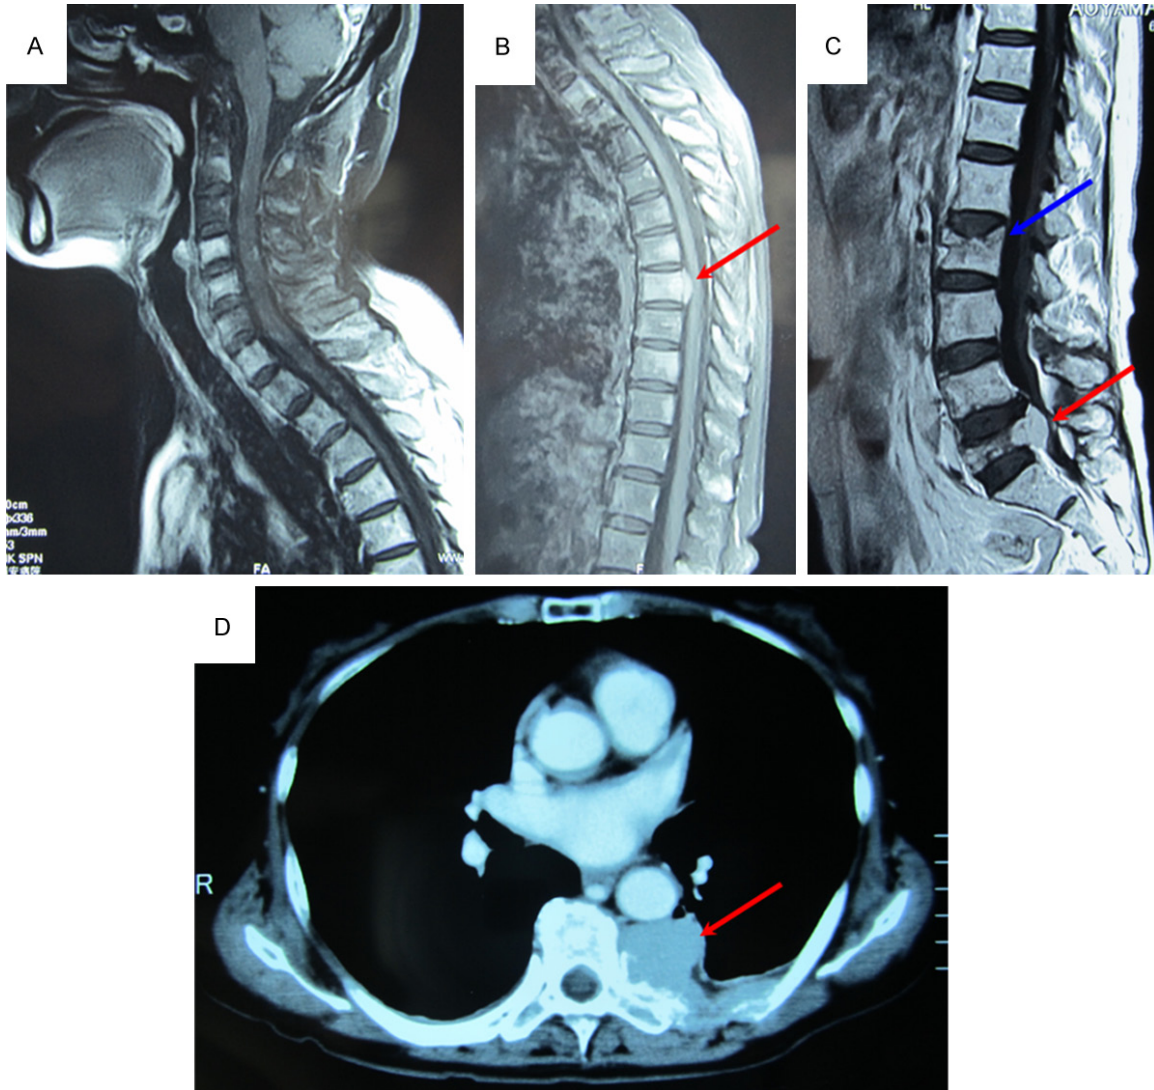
Imaging findings. A. Contrast-enhanced MRI of the cervical spine revealed many spotty signals in the cervical spine vertebral bodies, which were enhanced by gadolinium. B. Contrast-enhanced MRI of the thoracic spine revealed many spotty signals in the vertebral bodies of the thoracic spine, which were enhanced by gadolinium. Compression of the dural sac by an extraosseous lesion was observed (red arrow), suggestive of a plasmacytoma. C. Contrast-enhanced MRI of the lumbar spine revealed many spotty signals in the vertebral bodies of the lumbar spine, which were enhanced by gadolinium. There were compression fractures in L2 and L5 (blue arrow) and a soft tissue mass at L5 (red arrow), suggestive of a plasmacytoma. D. Contrast-enhanced chest CT revealed a soft tissue mass in the dorsal thoracic aorta (red arrow), suggestive of a plasmacytoma.
